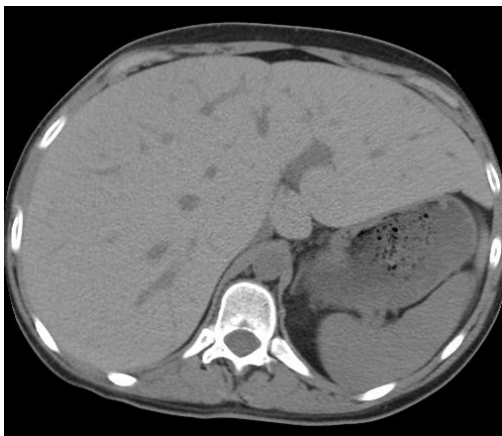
CT of the abdomen. The liver is enlarged and has increased attenuation at 82 Hounsfield units.
